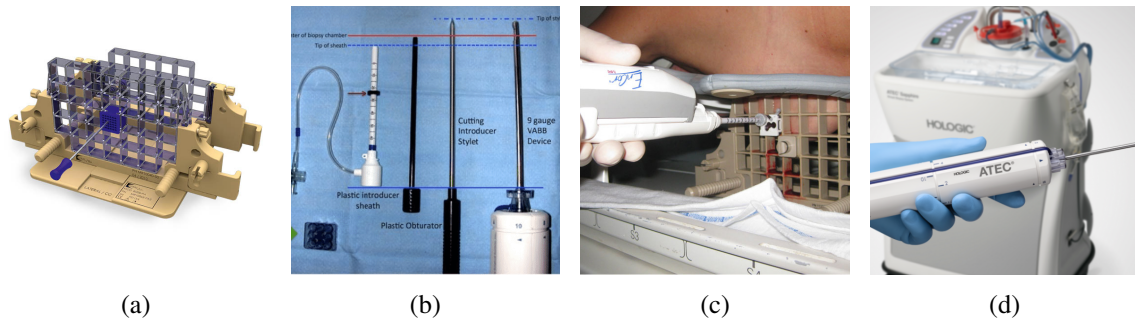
Equipment used for MRI Vacuum-assisted breast tissue biopsies (a)Grid structure [16]. (b) MRI equipment consisting of a plastic introducer sheath, obturator, Introducer Stylet and VABB device.[8]. (c) Biopsy taken [14]. (d) Vacuum-assisted biopsy needle [11].
